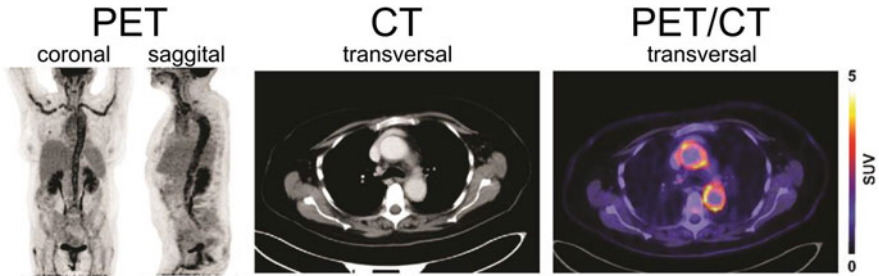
Using nuclear imaging to investigate fevers of unknown origin. Representative coronal, sagittal, and transversal [^{18}F]FDG PET/CT images of a patient presenting with recurrent FUO for 3 months and increasing C-reactive protein levels. [^{18}F]FDG PET shows inflammation of the large vessels consistent with Takayasu's arteritis. Adapted from [89] (CC-BY-4.0 license). © 2021, Iking et al.
